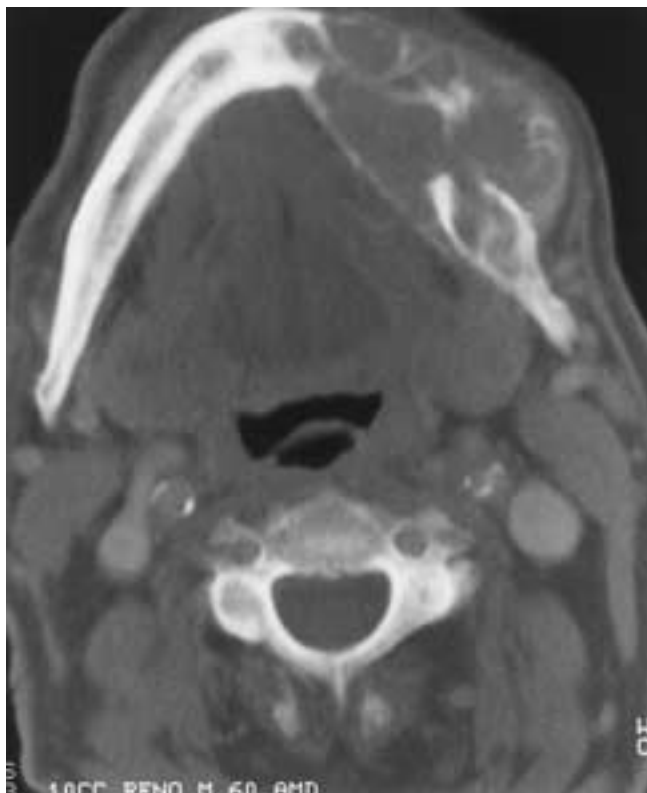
Giant cell granuloma of the left mandible. Axial CT (bone window setting) demonstrates a loculated, expansile lesion involving the ramus, body, and symphysis of the mandible.
